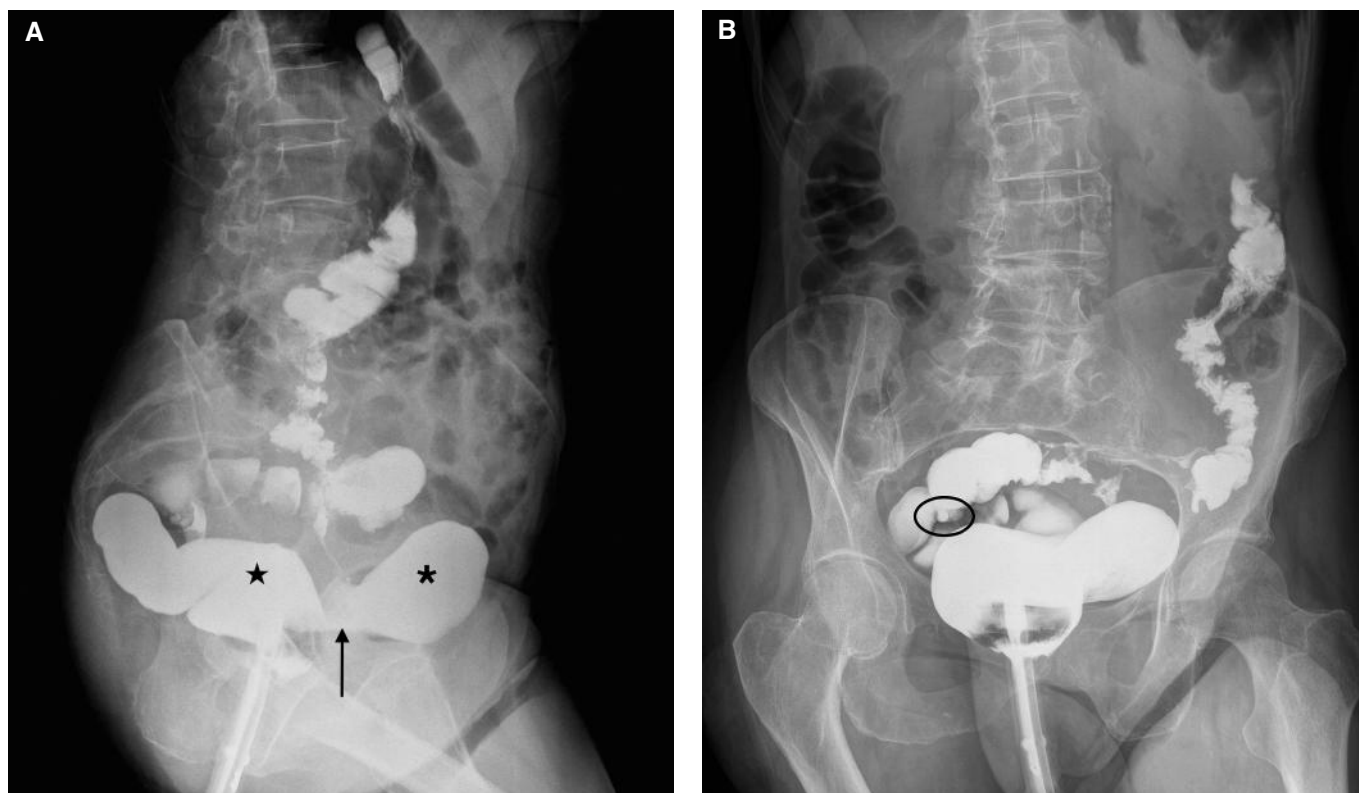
(A) LL and AP (B) roentgenograms showing the fistular tract (arrow) with extravasation of barium sulfate from bowel (star) to bladder (asterisk). Diverticula are evident along the whole sigmoid-descending colon (oval).
